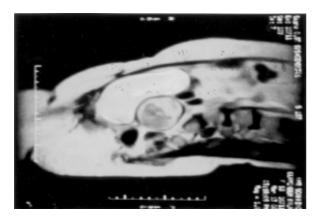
MRI Scan showing a midline well encapsulated lesion posterior to the bladder having solid and liquid components suggesting of malignant lesion.
